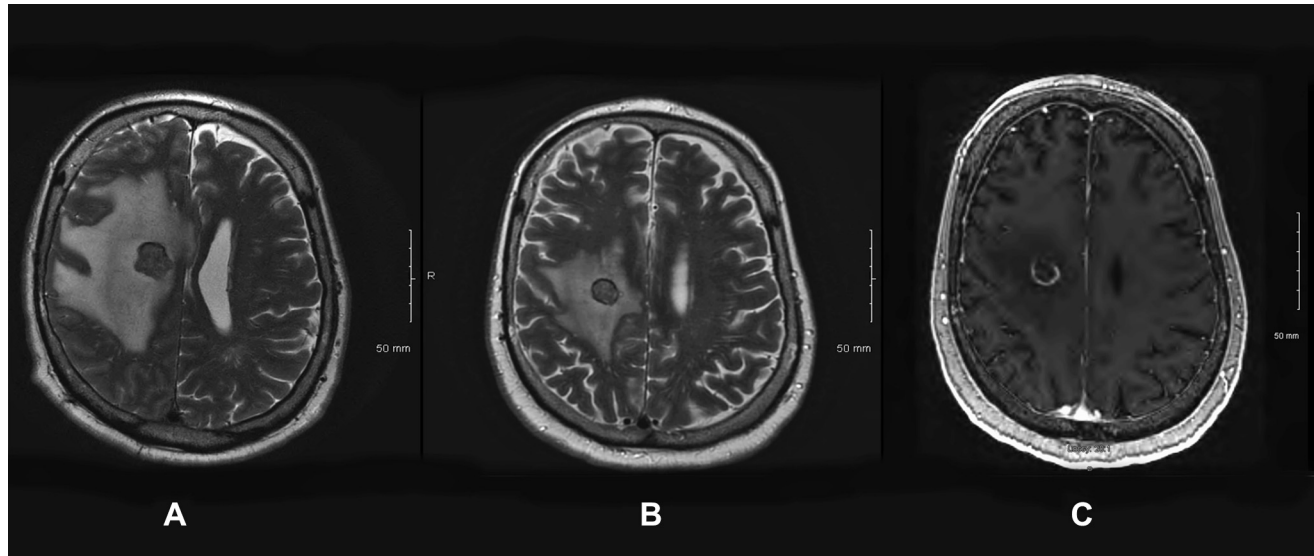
Representative T₂-weighted axial magnetic resonance images demonstrating cerebral edema in a 64-year-old man with a lung adenocarcinoma brain metastasis. (A) At presentation. (B) Fourteen weeks after stereotactic radiosurgery while the patient was receiving high-dose
